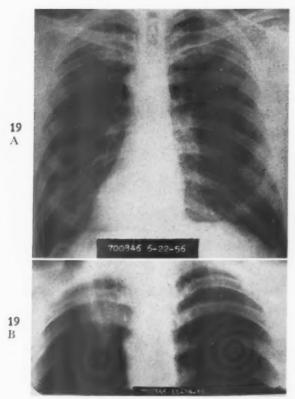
Case XIII. Chest roentgenograms. A, regular anteroposterior (B), planigram five months later showing left apical infiltrate without cavitation.
